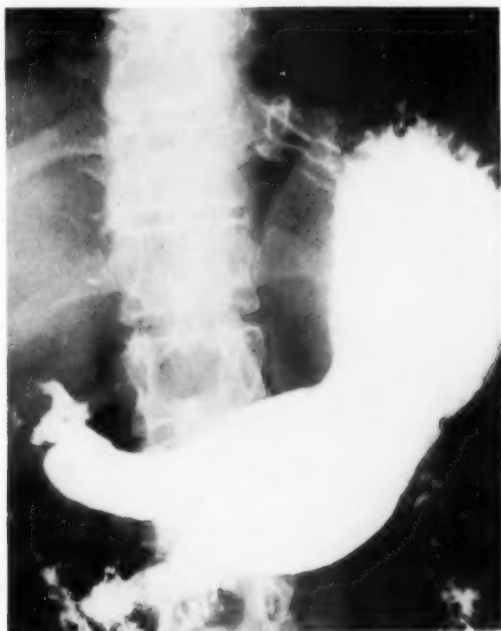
(Case 1). Roentgen picture of retrograde gastroesophageal mucosal prolapse.
